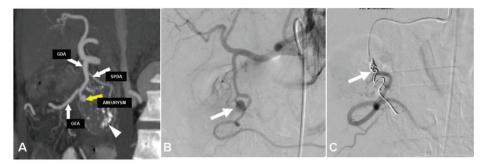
A 32-year-old male patient with tropical chronic pancreatitis (TCP) with haematemesis. Contrast CT (A) and DSA (B, C) images show calcifications in the head region (A, arrowhead) and pseudoaneurysm from gastroduodenal artery branch (A, yellow arrow; B arrow). Isolation of pseudoaneurysm achieved by coil trapping technique (C, arrow).
